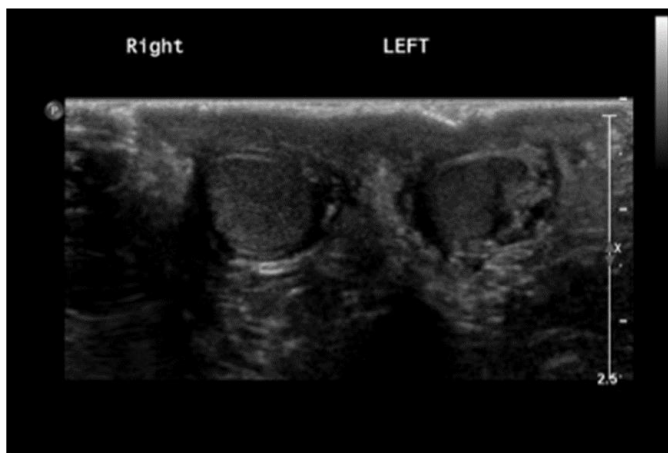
Ultrasound of testicles showed right testicles measures 1 x 0.8 x 1 cm and left testicle measures 1.4 x 0.8 x 0.8 cm.
